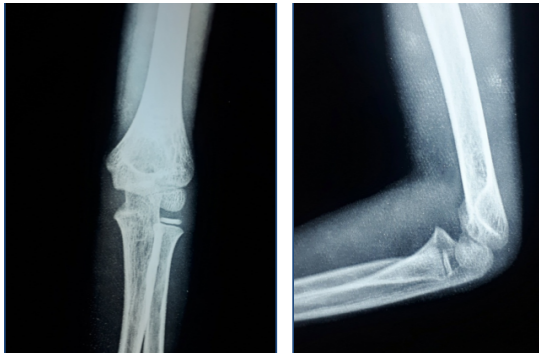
Showing complete anatomical union of fracture at 12 months follow-up following closed reduction and crossed pinning in both AP and Lateral views of X-ray
